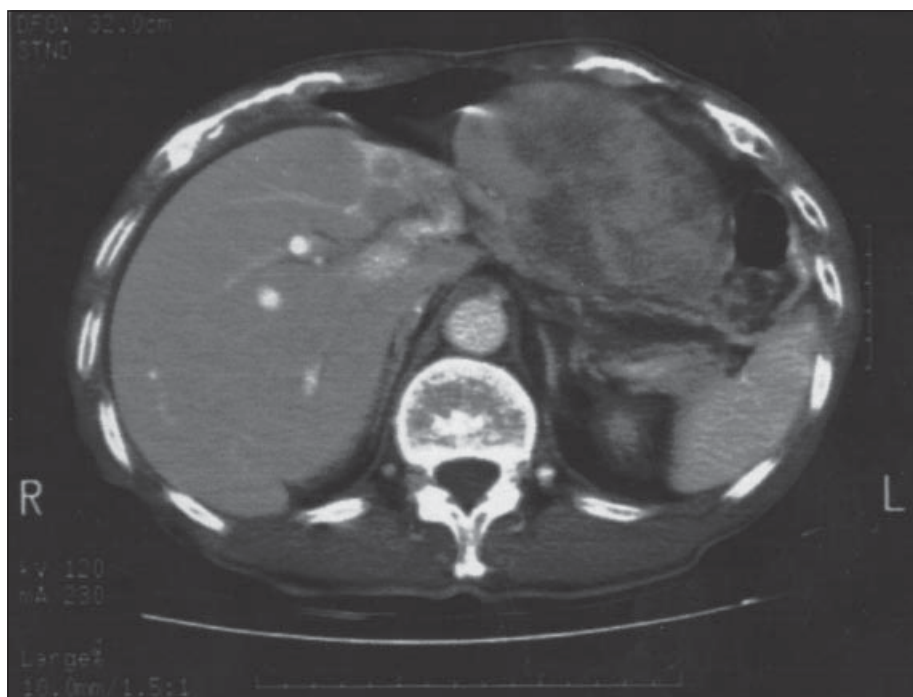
Abdominal computed tomographic scan of the patient
